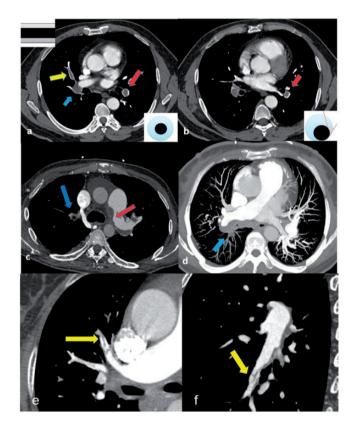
CT features of PTE: (a) acute PTE (transversal plane): filling defect of left lower pulmonary artery in "Polo mint" sign (red arrow) and filling defect of right middle pulmonary artery in "railway track" sign (yellow arrow), right lower lobe pulmonary artery occlusion (blue arrow); (b) acute PTE (transversal plane): the off-centered filling defect formed acute angles with the vessel wall (red arrow); (c) chronic PTE (transversal plane): the eccentric filling defect forming obtuse angle with the left pulmonary arterial wall (red arrow) and pouch defect of right upper pulmonary artery (blue arrow); (d) chronic PTE (maximum intensity projection): the eccentric filling defect forming obtuse angle with the right pulmonary arterial wall and pouch defect of right lower pulmonary artery (blue arrow); (e) chronic PTE (transversal plane): band-like filling defect of anterior superior lobe pulmonary artery (yellow arrow); and (f) chronic PTE (transversal plane): web-like filling defect of right lower lobe outer basal segment pulmonary artery (yellow arrow).
